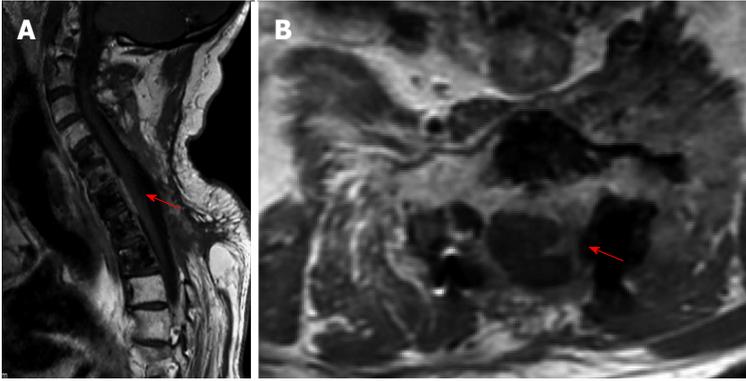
Cervical magnetic resonance imaging after radiation treatment showing (A) almost total disappearance of the mass and (B) axial view (red arrow).
